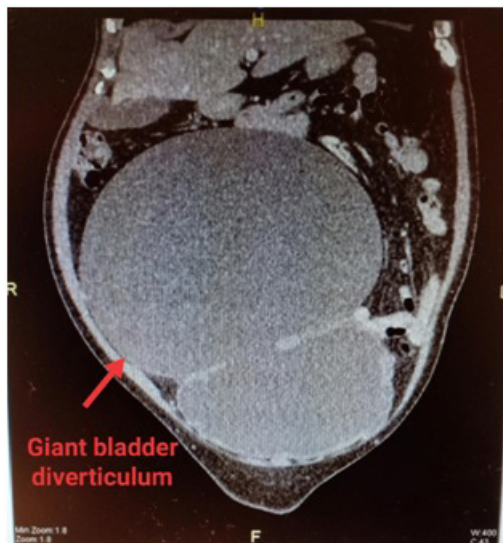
CT renal 4 phase shows a large well defined hypodense mass of fluid attenuation from superior urinary bladder, extend superiorly till L2 level measuring 15.6 x 22.4 x 18.2cm suggestive of giant urinary bladder diverticulum
